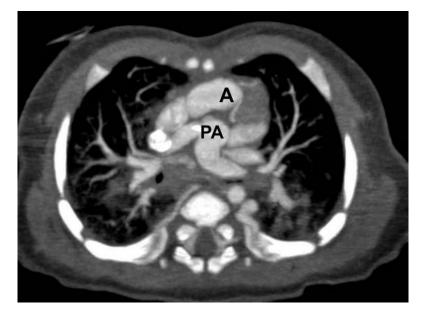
CT image shows L-TGA has a rtic root (A) locates anterior and leftward to the main pulmonary trunk (PA), this is assigned as "{_, _, L-TGA}".
